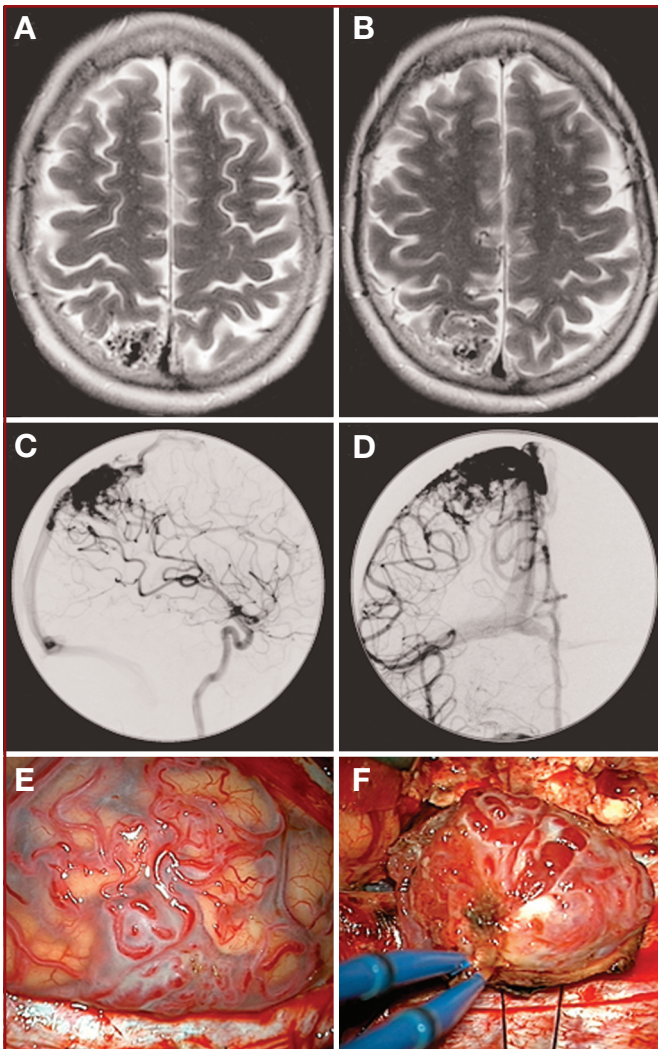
A 56-year-old woman who presented with an incidental, unruptured AVM in the right medial parietal lobe, just posterior to the somatosensory strip. A and B, axial T2-weighted magnetic resonance imaging (MRI) scans showing the AVM. C and D, angiograms (right ICA injection; C, lateral view; D, anteroposterior view) demonstrating superficial venous drainage and confirming a diffuse border laterally and posteriorly. Therefore, this patient had a Spetzler-Martin grade II AVM (S2V0E0) and a supplementary grade V (A3U1D1) (mismatched grades). E and F, intraoperative photographs showing resection of her AVM through a biparietal craniotomy. Although the resection was uncomplicated, she had new numbness in the left shoulder postoperatively. The supplementary grade was more predictive of her final outcome.
